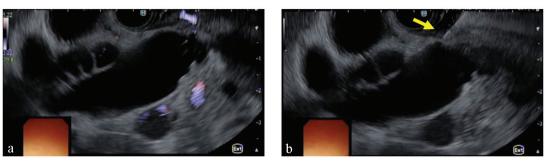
(a) Mucosal vessels are observed on endoscopic ultrasound using color Doppler imaging; (b) The sheath of the needle is advanced (arrow); by doing so, the vessel is compressed.
